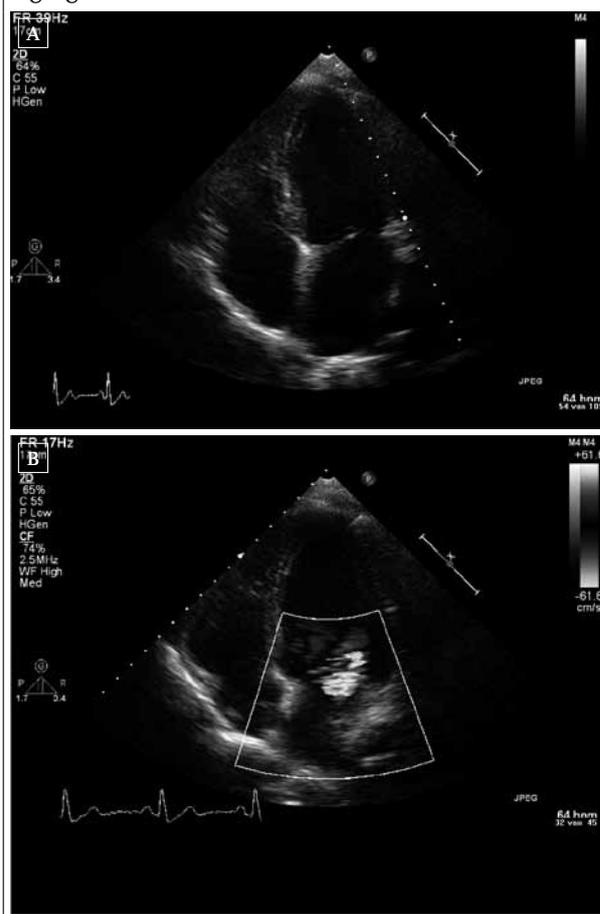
Echocardiography, apical four chamber view. A: Minimal mitral valve thickening. B: Moderate mitral regurgitation.
